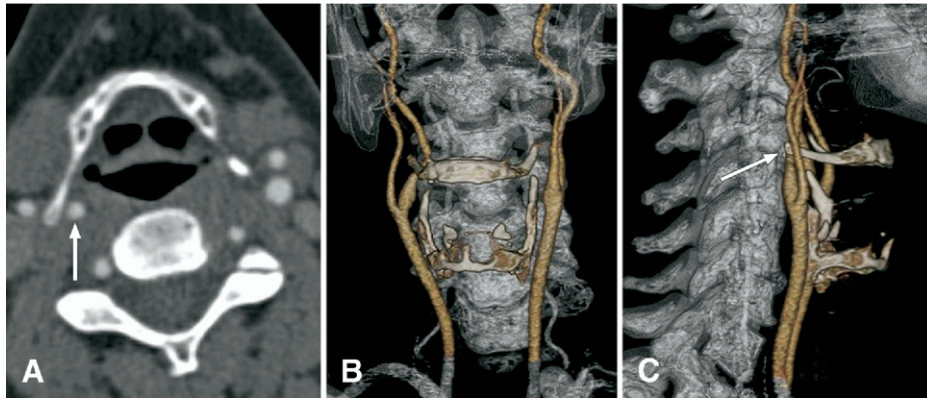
Computed tomography angiography of the neck. A, Multiplanar reconstruction (*MPR*) demonstrates the interposition of the right cornu of the hyoid bone between the right carotid arteries. The *arrow* indicates the right internal carotid artery. B, Anteroposterior and (C) lateral views of a three-dimensional reconstruction show the carotid artery and the cartilaginous and bony structures of the larynx and an osseous background. Note the low carotid bifurcation on the right side at C 4/5. C, The *arrow* points at the interposition of the right cornu of the hyoid bone between the right carotid artery.
